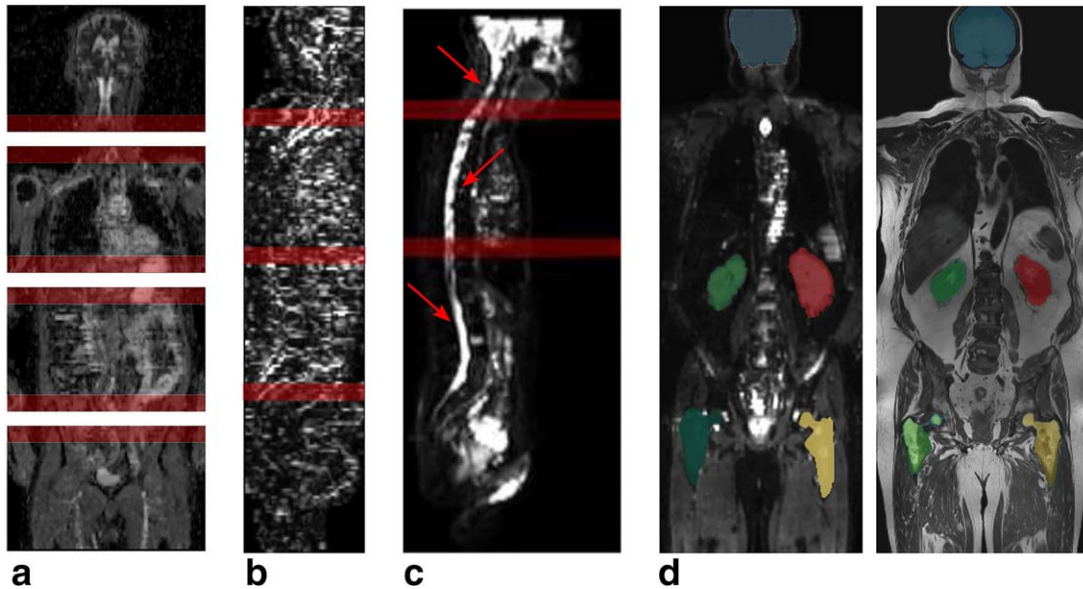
Visual representation of the used evaluation criteria. a: Registered ADC image stations with the overlay region marked in red. Averaged mean absolute differences in the inter-station overlay region was measured. b: Edge image calculated along cranio-caudal direction from mosaicked ADC whole-body image. Average edge intensity was measured in the inter-station overlay region (red). c: b0 whole-body image. The spinal cord was manually segmented from head, torso, and pelvis b0 image stations prior to the registration (red arrows). Alignment of the segmented structures was evaluated using the Dice coefficient in the station overlay region (red). d: Five different organs were manually segmented from the whole-body T₁ (right) and the corresponding DWI image (left) prior to the registration. Inter-modality organ alignment accuracy was measured with the Dice coefficient.
